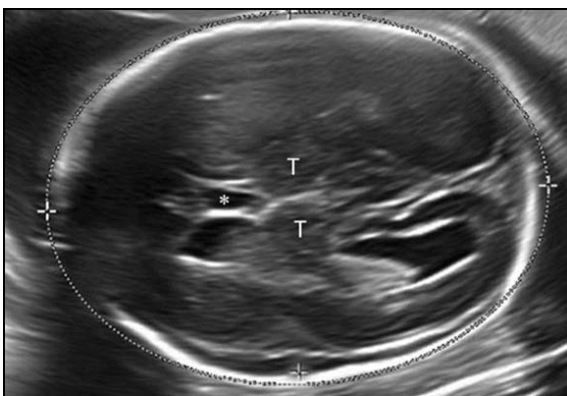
Ultrasound show Fetal Head Circumference, Abdominal Circumference and Femur Length
